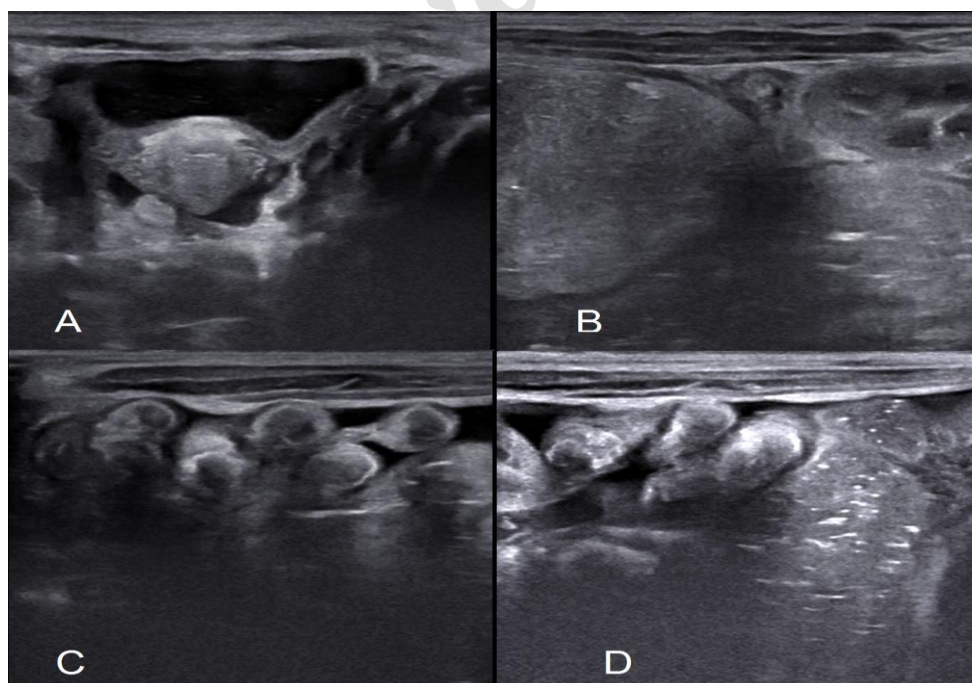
(A-D): The abdominal ultrasonography findings of meconium ileus; A) dilated proximal loops with floating flakes of air in meconium fluid on proximal dilated loops as the reason of soap bubble sign. B) The descending colon in front of the left kidney and posterior to dilated proximal loops. C and d) the bowel loops contain inspissated meconium as hypoechoic tubular or beaded intraluminal material in comparison with its bowel wall.
